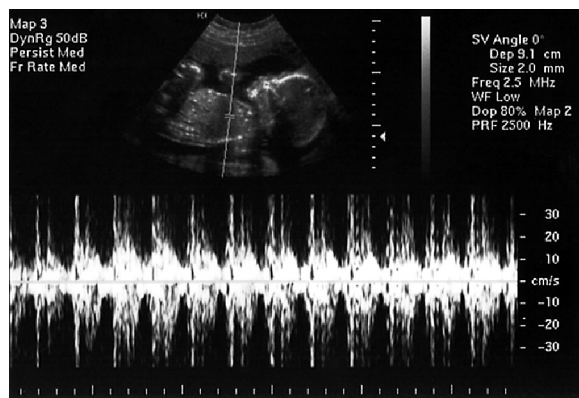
Ultrasound picture of a fetus at 23 weeks of gestation (top), with a Doppler study of the fetal heart (bottom). Dop, Doppler; Fr, frame; Freq, frequency; PRF, pulse-repetition frequency; SV, sample volume; WF, wall filter. (Courtesy Frank Fox, RDMS.)
